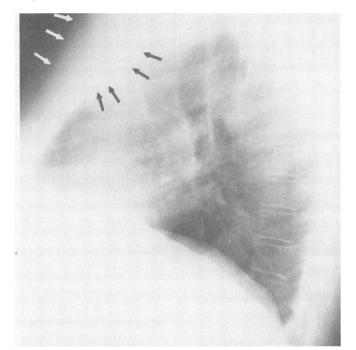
A lateral chest x-ray film shows soft tissue swelling and destruction of the sternum (arrows) in patient 1.
